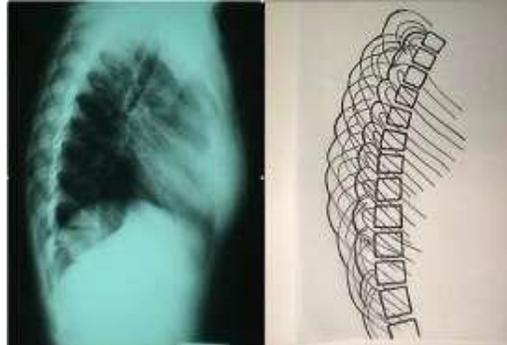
The DRCS in lateral radiographs, (from Grivas et al 2002, [116]).
